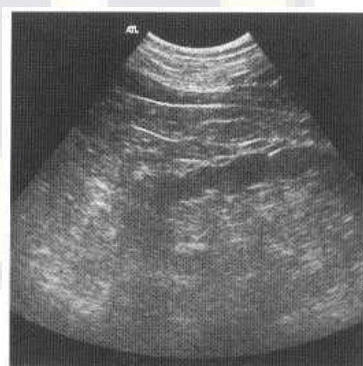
Renal ultrasound demonstrating the characteristic pattern of persistent fetal lobulation.
